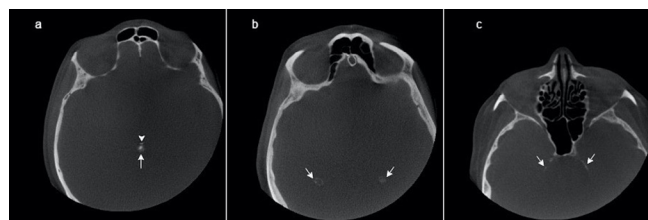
Axial CBCT images show (a) habenular calcification (short arrow), pineal gland calcification (arrow), (b) choroid plexus calcification (arrowheads), (c) petroclinoid ligament calcification (arrowheads).
